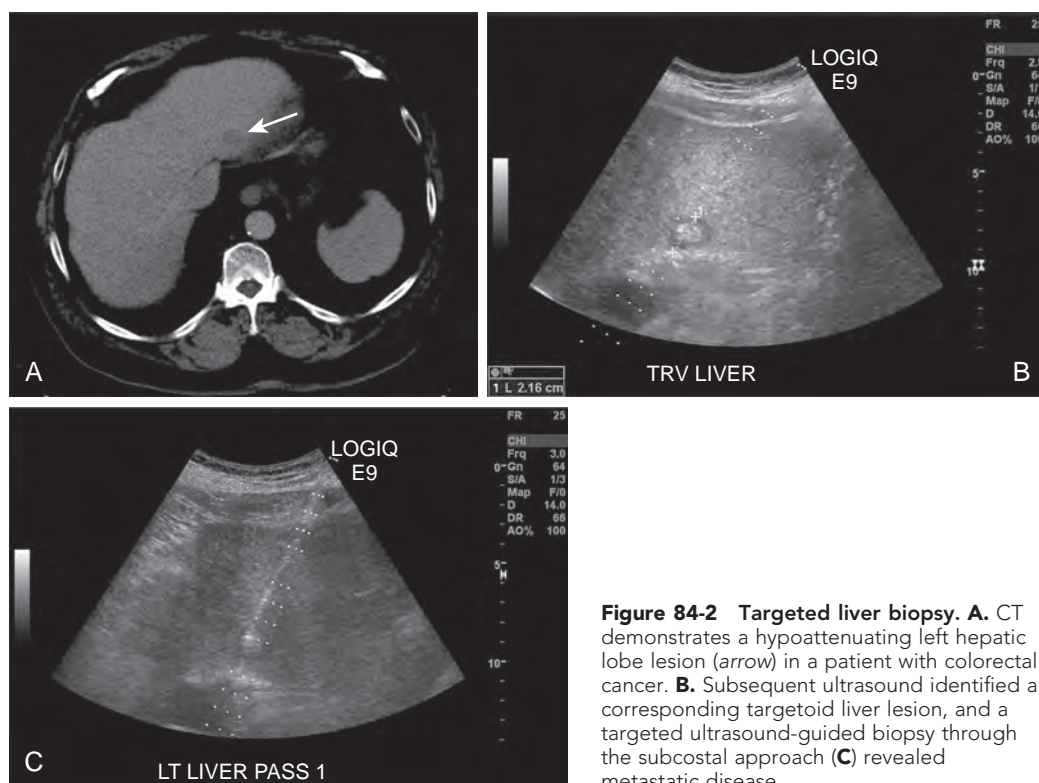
Targeted liver biopsy. A. CT demonstrates a hypoattenuating left hepatic lobe lesion (arrow) in a patient with colorectal cancer. B. Subsequent ultrasound identified a corresponding targetoid liver lesion, and a targeted ultrasound-guided biopsy through the subcostal approach (C) revealed metastatic disease.
